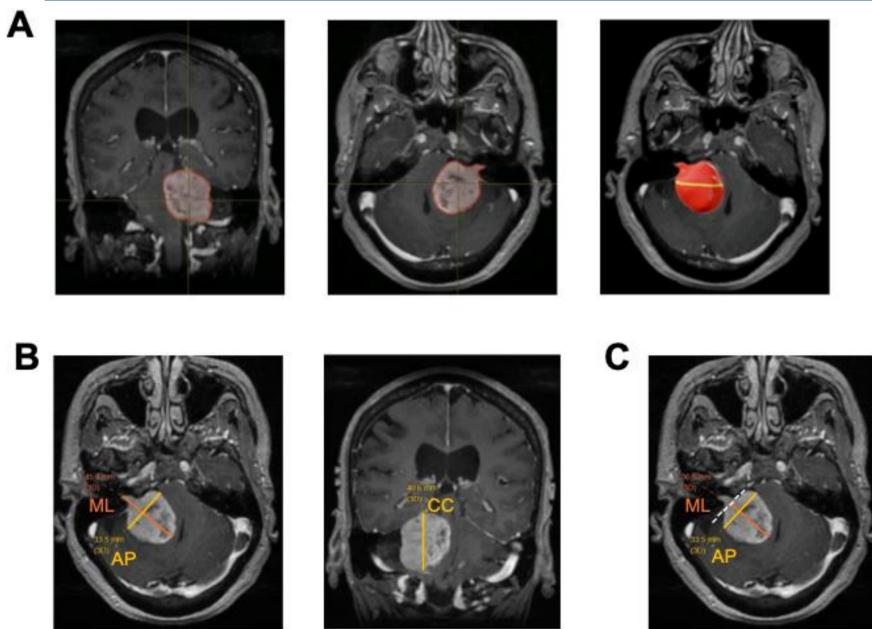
Measurement methods compared on a representative preoperative contrast-enhanced T1-weighted MRI. (A) Volumetric segmentation (reference standard): slice-by-slice contouring in BrainLab, yielding volume in cm³. (B) Anteroposterior (AP), mediolateral (ML), and craniocaudal (CC) dimensions used to calculate ABC/2 ellipsoid volume (AP × ML × CC / 2, cm³) and maximum linear dimension (MLD, largest of the three, mm). (C) AAO-HNS extrameatal diameter: √(extrameatal AP × ML), mm. Koos grade (I–IV, not shown) classifies tumor extent relative to the internal auditory canal and brainstem.
